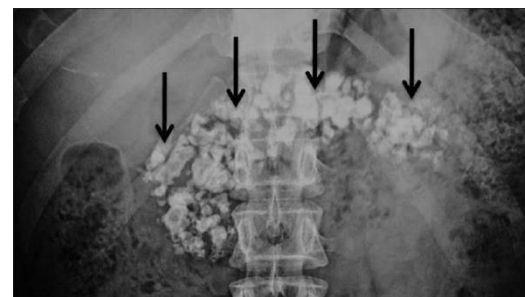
Plain abdominal radiograph; chronic pancreatitis. Multiple opacities can be seen in the region of the head and tail of the pancreas
